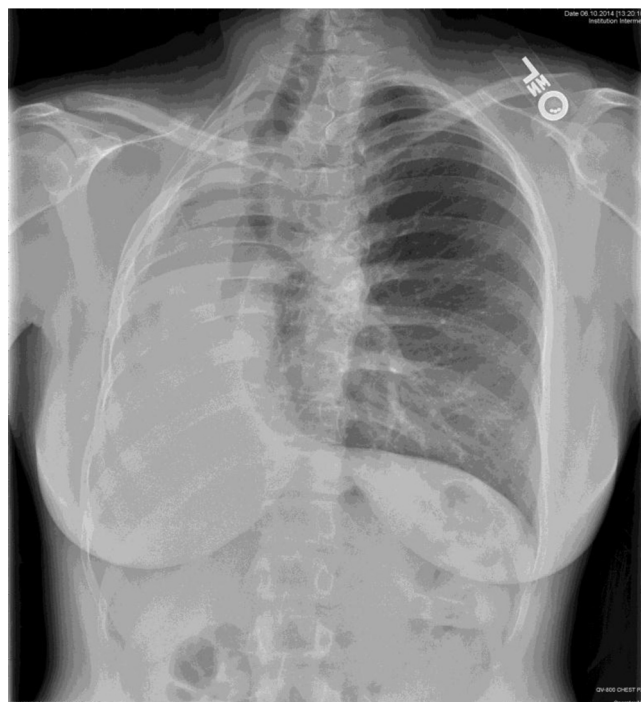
Chest x-ray at 23 years.
